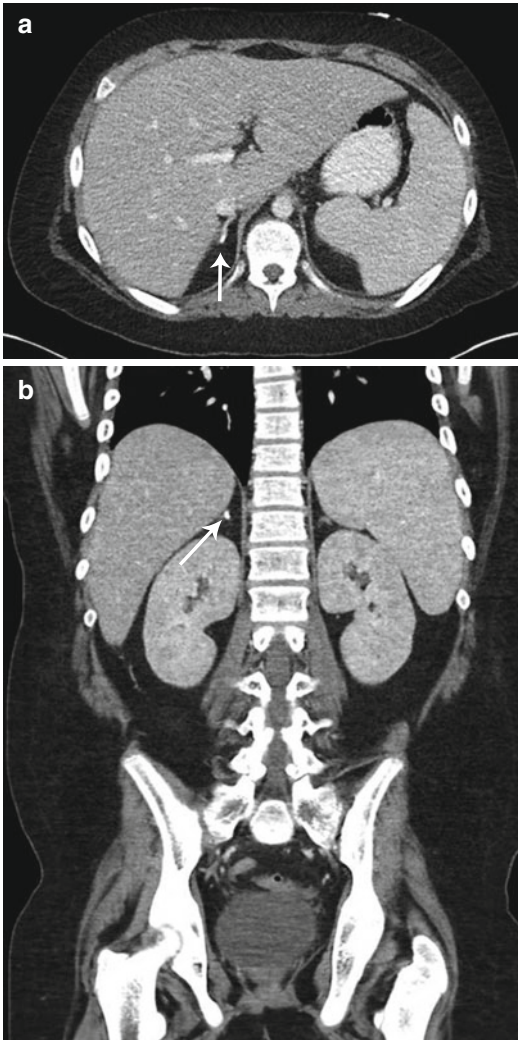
Old adrenal hemorrhage. Axial (a) and coronal (b) contrast-enhanced CT images of the abdomen in a 10-year-old boy reveal a small focus of calcification in the right adrenal gland (arrows) with no associated soft tissue mass, presumed the sequela of prior adrenal hemorrhage
